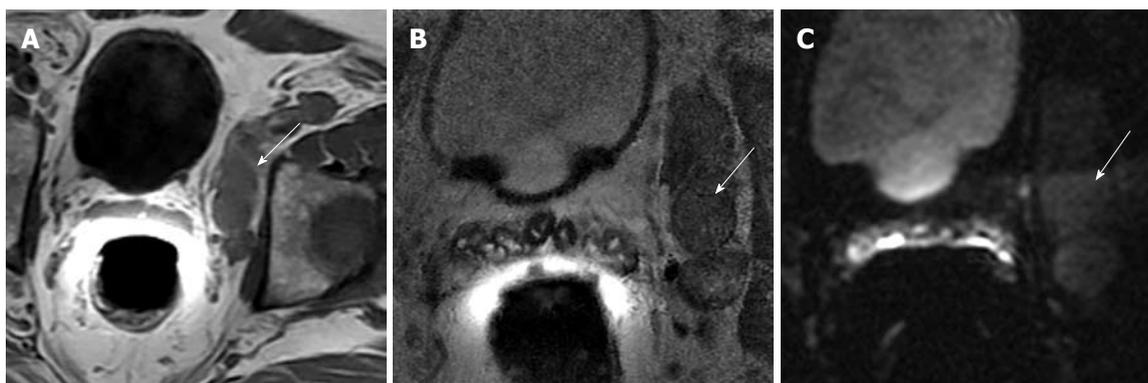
MR depiction of malignant adenopathy from prostate cancer in a 63-year-old man with Gleason score 4 + 5 and PSA level of 24 ng/mL. Transverse 5 mm-thick T1-WI (600/8) (A) and transverse 3 mm-thick T2-WI (5450/118) (B) show intermediate SI bulky adenopathy (arrows) with short-axis dimensions of > 10 mm is present in left external iliac and obturator distributions; C: Transverse 3 mm-thick DWI (3500/98, b-value of 1000 s/mm²) show intense, increased signal (restricted diffusion) throughout the mass (arrow).
